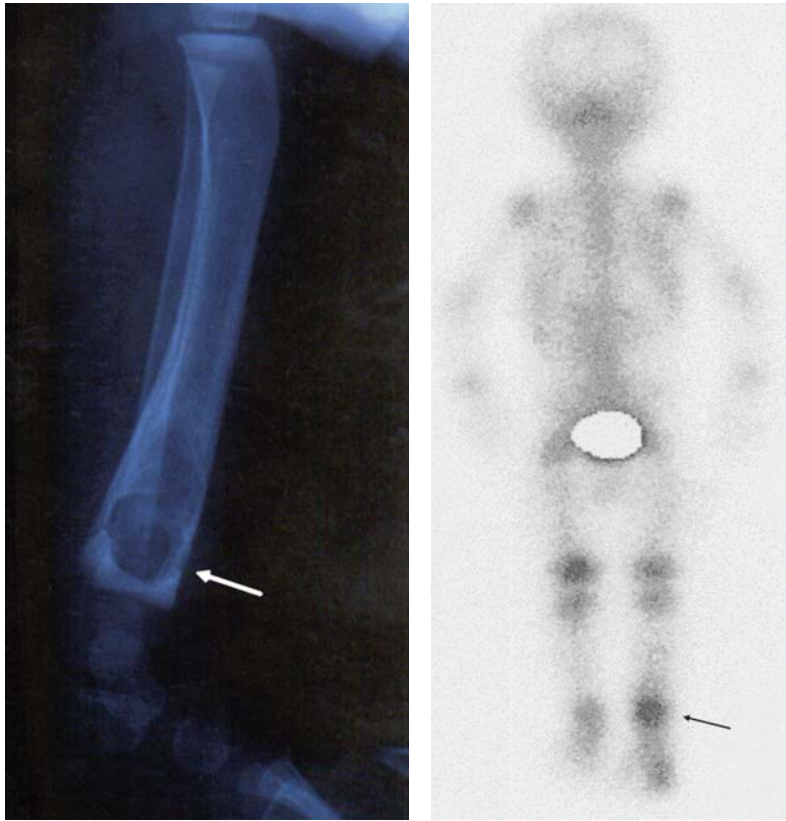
Osteomyelitis in a patient with dominant partial-IFN- γ R1 deficiency. a: Radiograph of the left shin showing osteolytic lesion in the left tibia (white arrow). b: Skeletal scintigram, showing an area of increased uptake of technetium in the distal end of the left tibia (black arrow).
